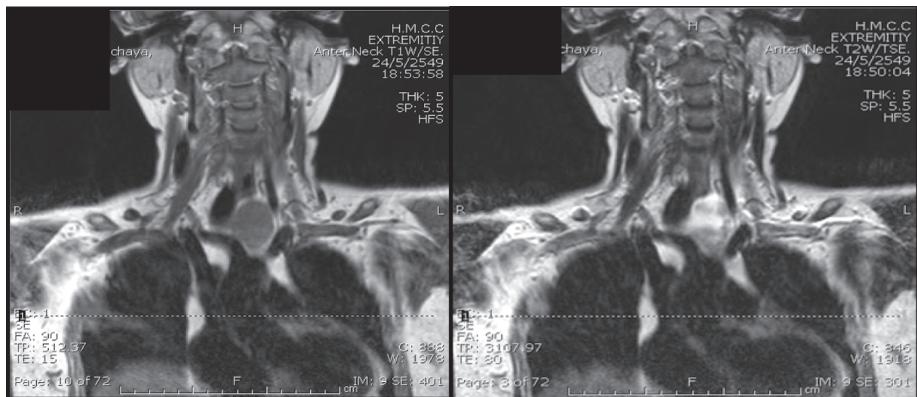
MRI study of the neck revealed cystic soft tissue mass situated just below the thyroid gland, 38x36x40 mm in size
